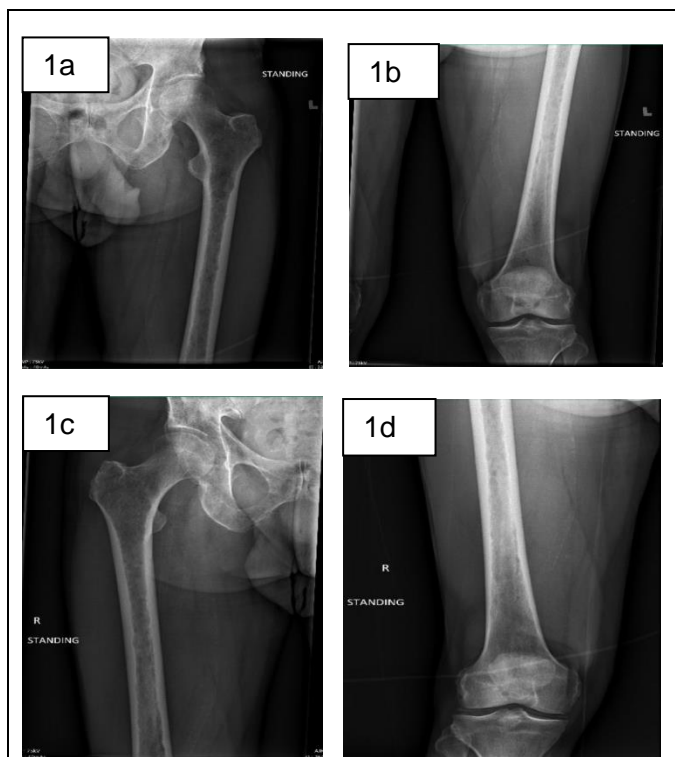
X-rays from the skeletal survey specific to the bilateral femurs, taken at the time of diagnosis. (1a) AP view of the proximal left femur, demonstrating multiple lytic lesions throughout the bone, with the subtrochanteric lesion most prominent. (1b) AP view of the distal left femur, demonstrating multiple lytic lesions throughout the bone. (1c) AP view of the proximal right femur, demonstrating multiple lytic lesions throughout the bone. (1d) AP view of the distal right femur, demonstrating multiple lytic lesions throughout the bone with the distal femoral shaft lesion most prominent.
